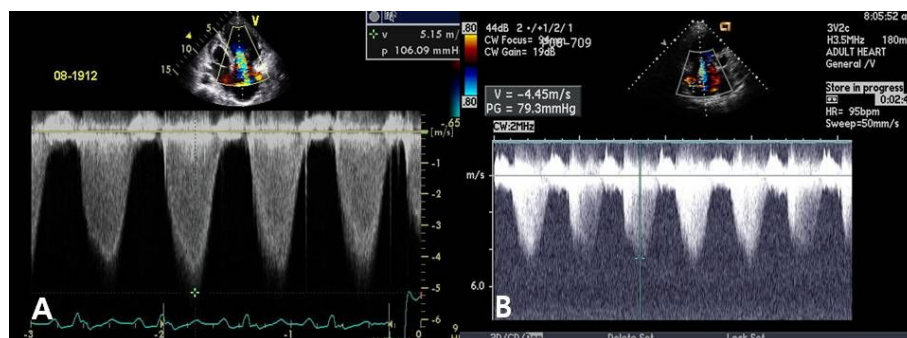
(A) Echocardiography at admission shows 5.15 m/s tricuspid regurgitant (TR) jet velocity. (B) After the use of iloprost, TR jet velocity decreased to 4.45 m/s.
